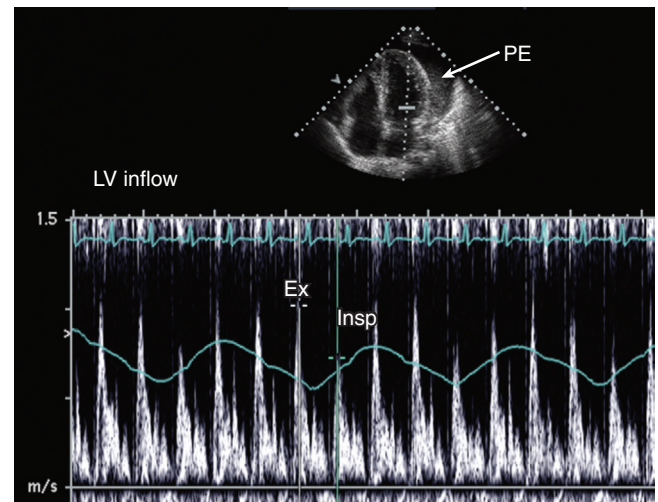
■ Pericardial effusion (PE) in a patient with dyspnea. The transmitral pulsed Doppler tracing demonstrates respiratory variation in flow. Ex, Expiration; Insp, inspiration.
